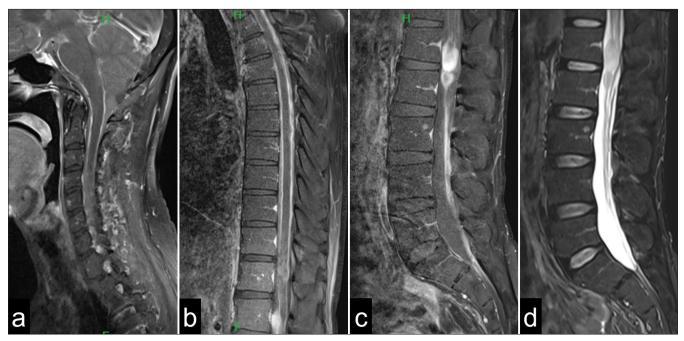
Sagittal magnetic resonance imaging of the (a) cervical spine, (b) thoracic spine, and (c and d) lumbar shows leptomeningeal thickening and postcontrast enhancement around the entire spinal cord. In addition, T2-weighted images reveal a (c) contrast-enhancing and (d) high-intensity mass lesion at the L1 level.
